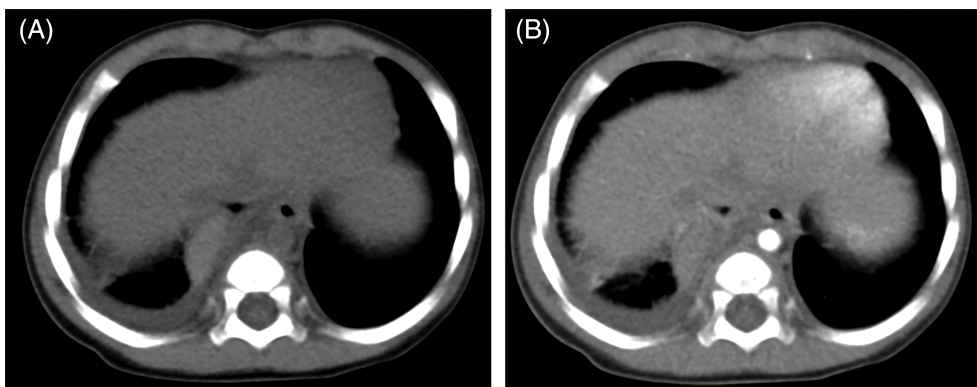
(A) Chest computed tomography showed a homogeneous solid mass in the right lower thorax (arrow), pleural effusion was also identified (E). (B) Contrast medium-enhanced chest computed tomography showed the edge of the mass with slight linear reinforcement and no reinforcement in its interior (arrow).
